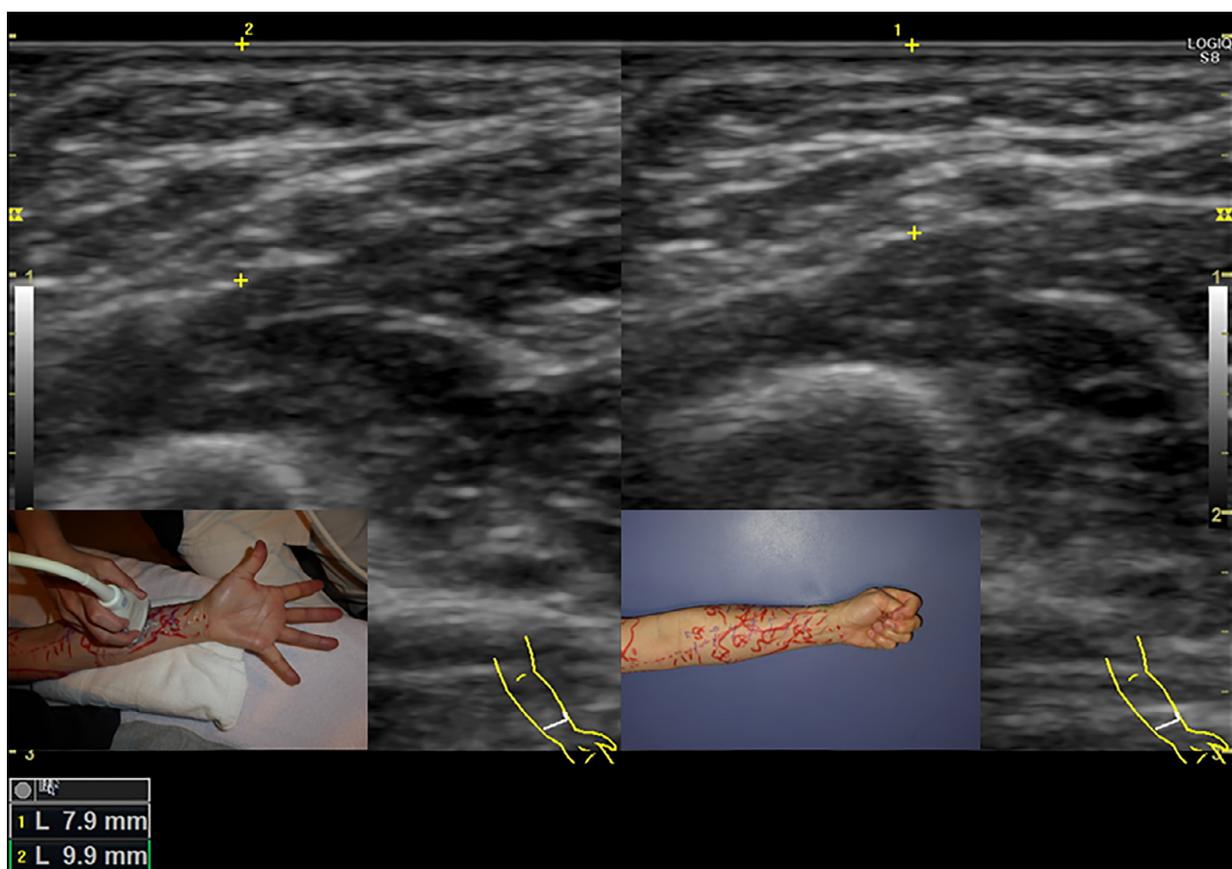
Determining the incision point in the dynamic-lymphaticovenular anastomosis (dynamic-LVA) method. On the lymph line, transverse marks are made at 1.5 cm increments starting at the distal end of the line. Dynamic ultrasonography is performed at all marks along the lymph line tracing. With a grasping motion (systolic phase), the soft tissue that includes lymphatic vessels and veins for LVA is compressed between the skin surface and the deep fascia, and with a hand-opening motion (diastolic phase), the soft tissue is released. Effective venous pumping is evaluated on the basis of the existence of a blood-filled subcutaneous vein larger than 1.0 mm in diameter and/or a marked between-phase difference in the thickness of the soft tissue. (Right) In the case depicted, because no pumped subcutaneous vein larger than 1.0 mm in diameter was seen at any of the marks in the systolic phase, the thickness of the soft tissue was measured at each mark in the systolic and diastolic phases. In the systolic phase, the soft tissue was 7.9 mm thick at the third mark. (Left) In the diastolic phase, the soft tissue was 9.9 mm thick at this mark. Thus, the third mark was selected as the incision site because 2.0 mm was the greatest between-phase difference found in the thickness of the soft tissue at the lymph line.
